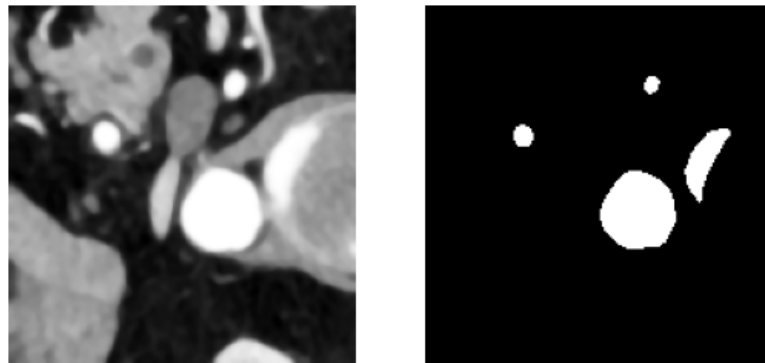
CTA before and after the thresholding. (Patient 1)
